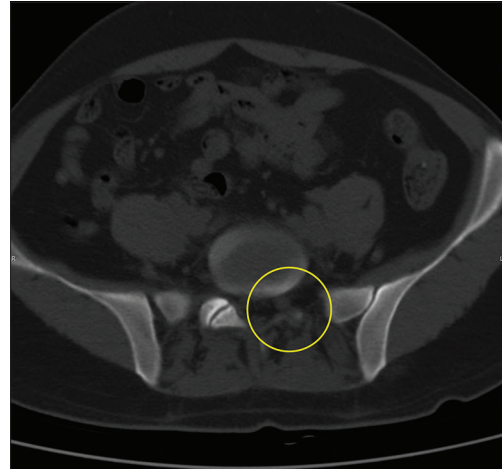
Axial computed tomography scan cut of the spine showing the absence of the L5–S1 facet joint on the left side.
